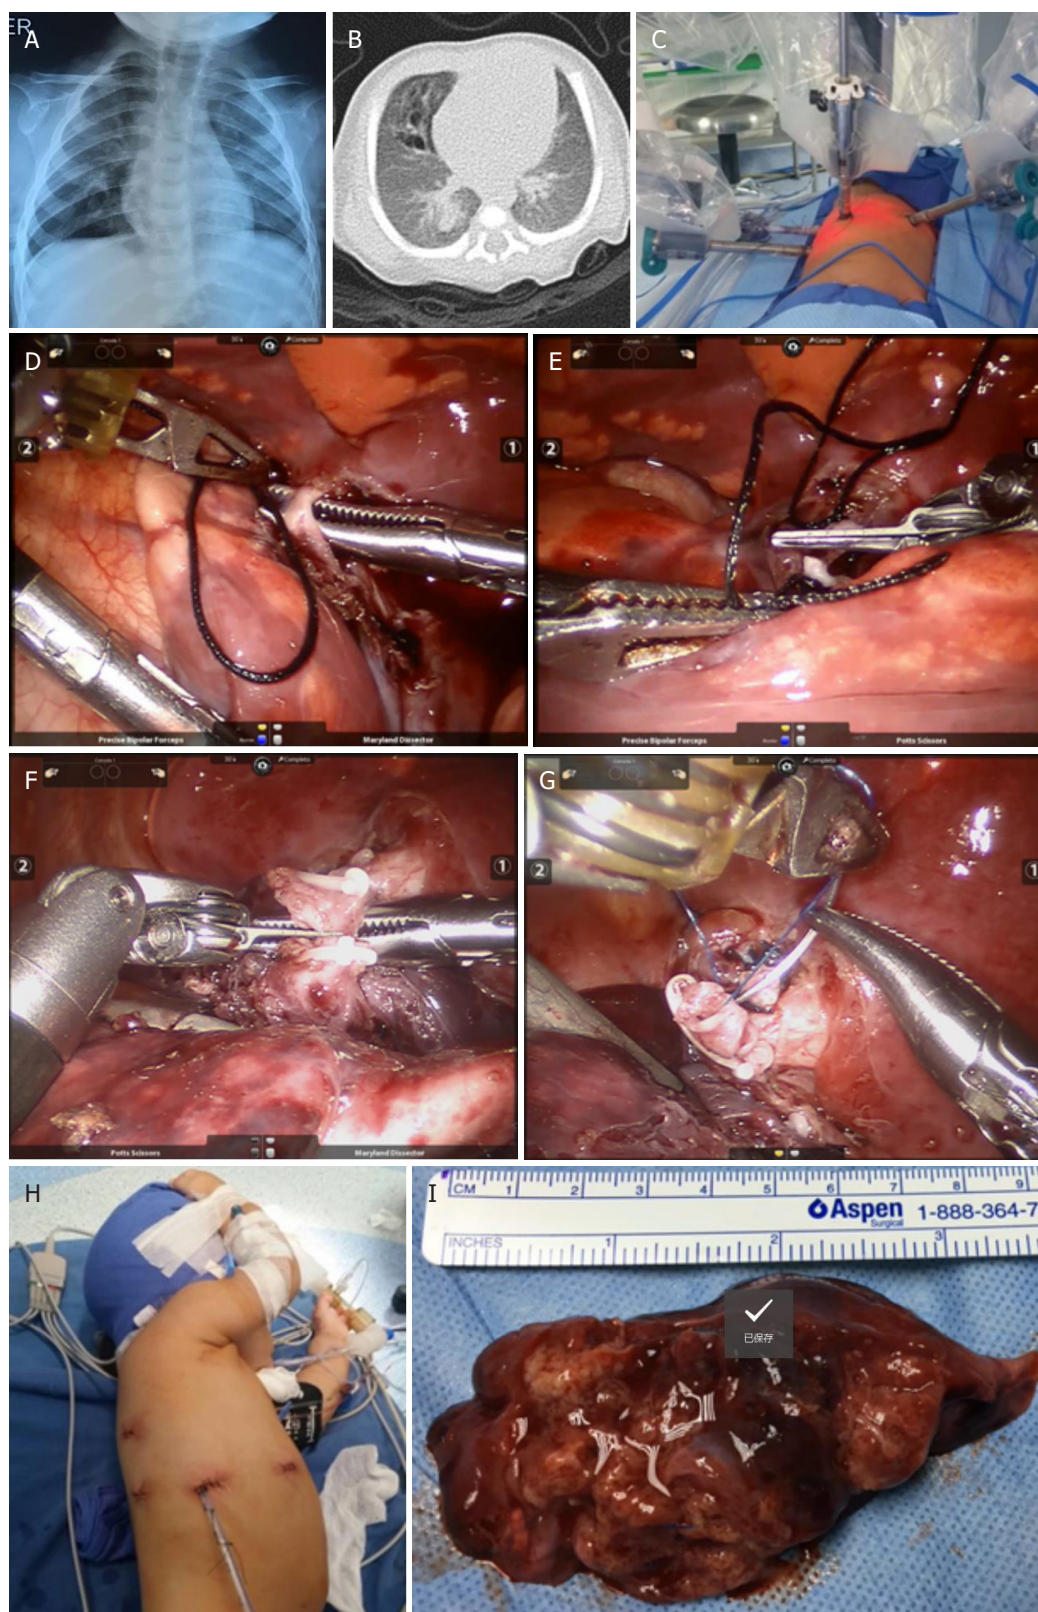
Robotics lobectomy technique in an infant patient. Female patient, 10 months old and 5.93 kg in weight. A, B: chest X-ray and CT scan image showing the right lower lobe affected by CCAM; C: location of the two 8-mm robot instrument trocars, an 8.5-mm trocar for camera lens, and an auxiliary 5-mm trocar in the right hemithorax and cephalic docking; D, E: IO images, dissection, ligation, and cutting of the pulmonary vein of the affected lobe; F, G: IO images, management of the lobular bronchus with hemoclip and suture; H: the complete lobectomy and pleural tube emerge through the wound to the trocar of the camera lens; I: the surgical piece was removed through the trocar wound of the camera lens. CCAM: congenital cystic adenomatoid malformation; IO: Intraoperative
